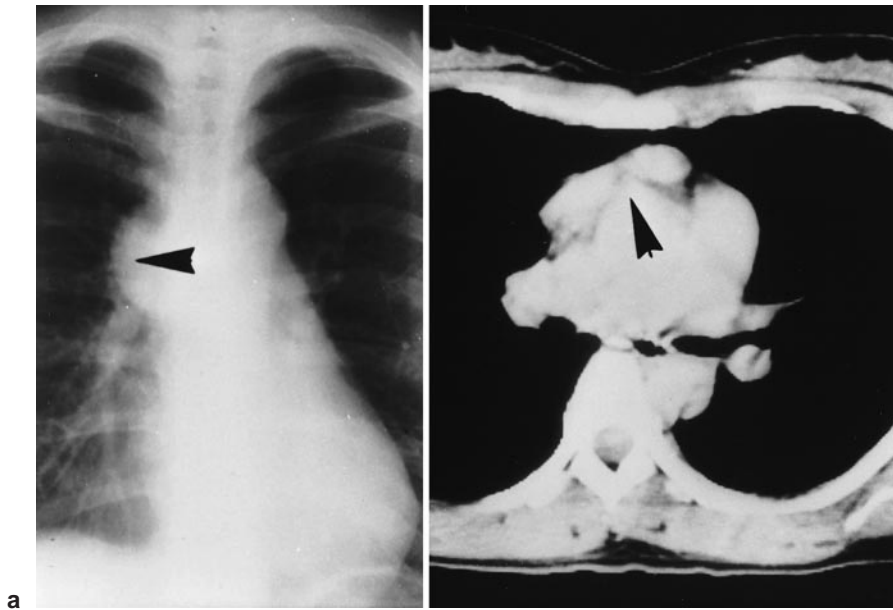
a Chest roentgenogram and b chest computed tomographic scan of case 1 show two masses (*arrows*) in the anterior mediastinum
